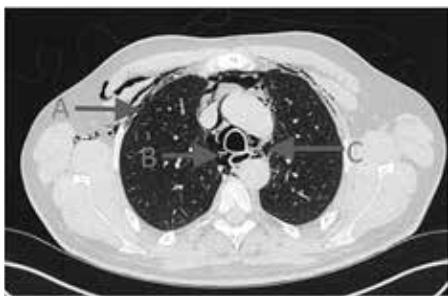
Axial CT showing air in the pleural space (A) and mediastinum (B, C).
